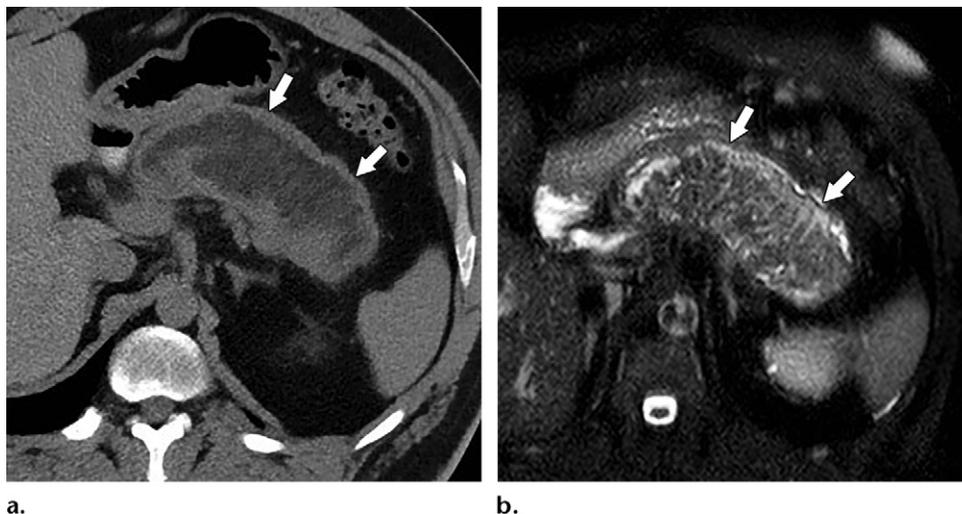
Necrotizing pancreatitis in a 47-year-old man in week 16 of persistent symptoms. (a) Axial nonenhanced CT image shows pancreatic WON involving nearly the entire pancreas (arrows); at least half of its volume appears to contain fluid. (b) Subsequent axial fat-saturated T2-weighted MR image shows the WON (arrows) containing mostly nonliquefied debris and pancreatic necrosis, with little fluid present. Such a collection would respond poorly to percutaneous or endoscopic drainage and would require more aggressive therapy.
